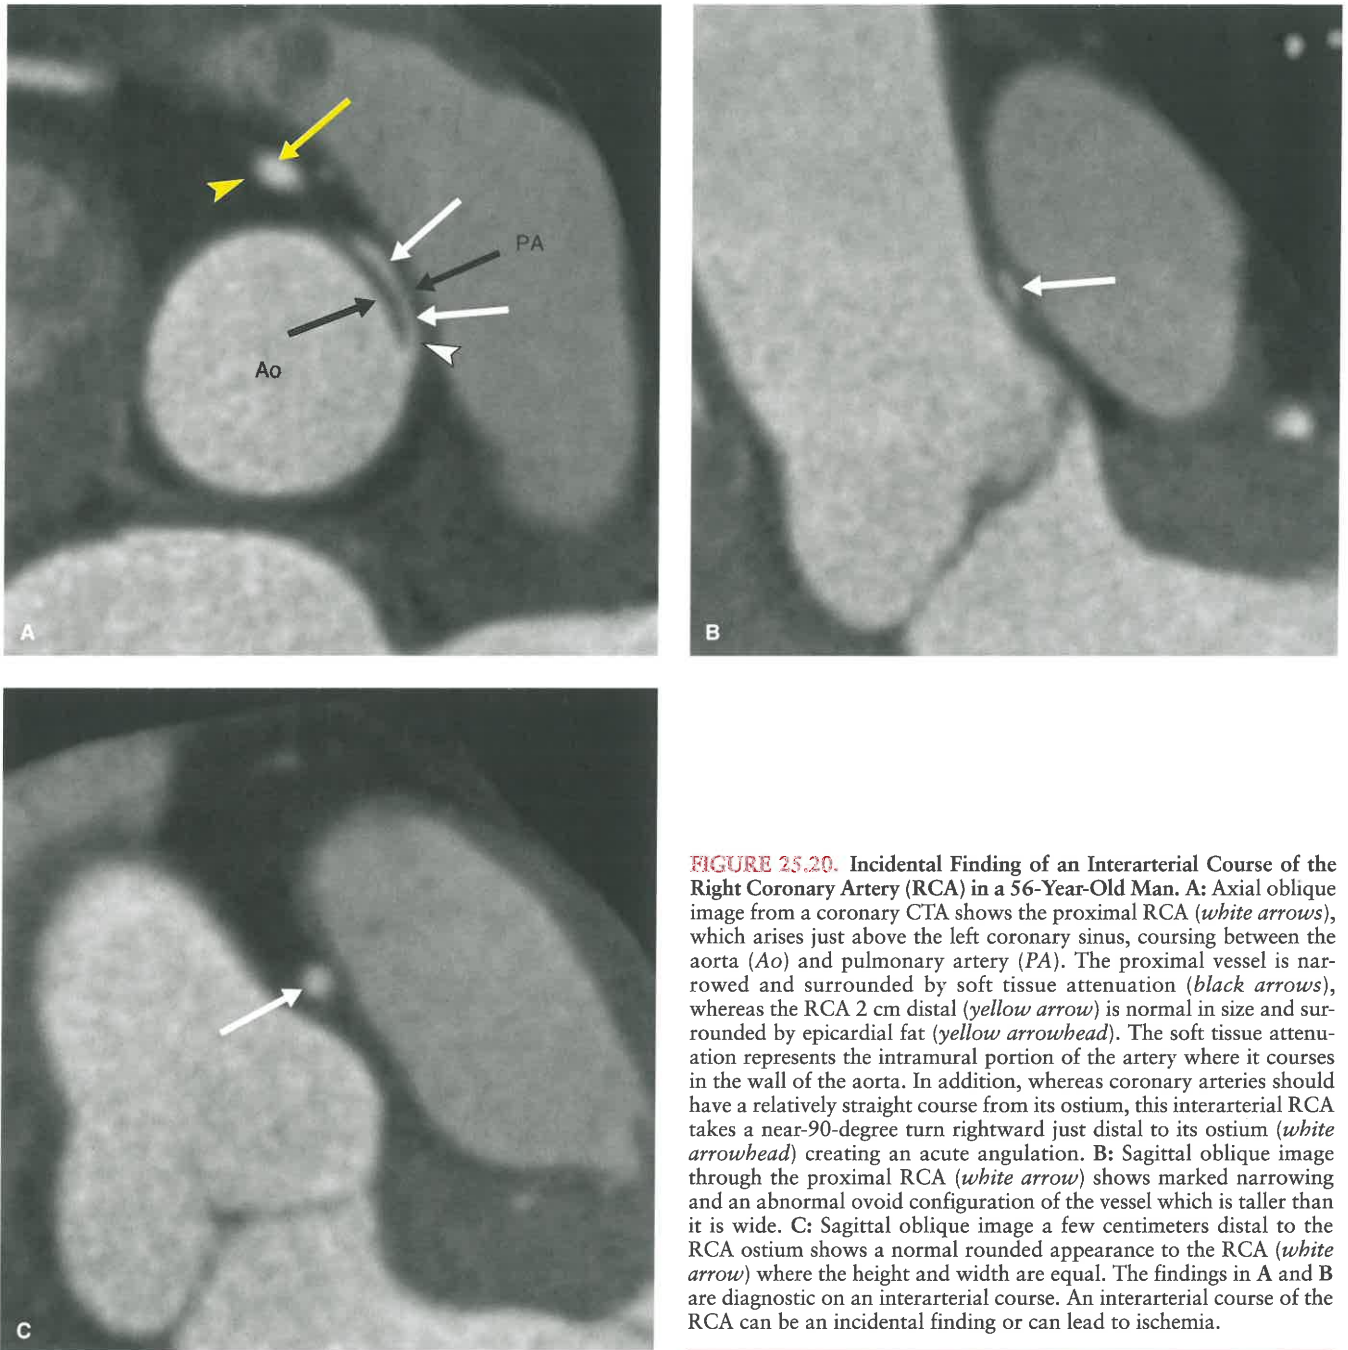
Incidental Finding of an Interarterial Course of the Right Coronary Artery (RCA) in a 56-Year-Old Man. A: Axial oblique image from a coronary CTA shows the proximal RCA (*white arrows*), which arises just above the left coronary sinus, coursing between the aorta (Ao) and pulmonary artery (PA). The proximal vessel is narrowed and surrounded by soft tissue attenuation (*black arrows*), whereas the RCA 2 cm distal (*yellow arrow*) is normal in size and surrounded by epicardial fat (*yellow arrowhead*). The soft tissue attenuation represents the intramural portion of the artery where it courses in the wall of the aorta. In addition, whereas coronary arteries should have a relatively straight course from its ostium, this interarterial RCA takes a near-90-degree turn rightward just distal to its ostium (*white arrowhead*) creating an acute angulation. B: Sagittal oblique image through the proximal RCA (*white arrow*) shows marked narrowing and an abnormal ovoid configuration of the vessel which is taller than it is wide. C: Sagittal oblique image a few centimeters distal to the RCA ostium shows a normal rounded appearance to the RCA (*white arrow*) where the height and width are equal. The findings in A and B are diagnostic on an interarterial course. An interarterial course of the RCA can be an incidental finding or can lead to ischemia.
